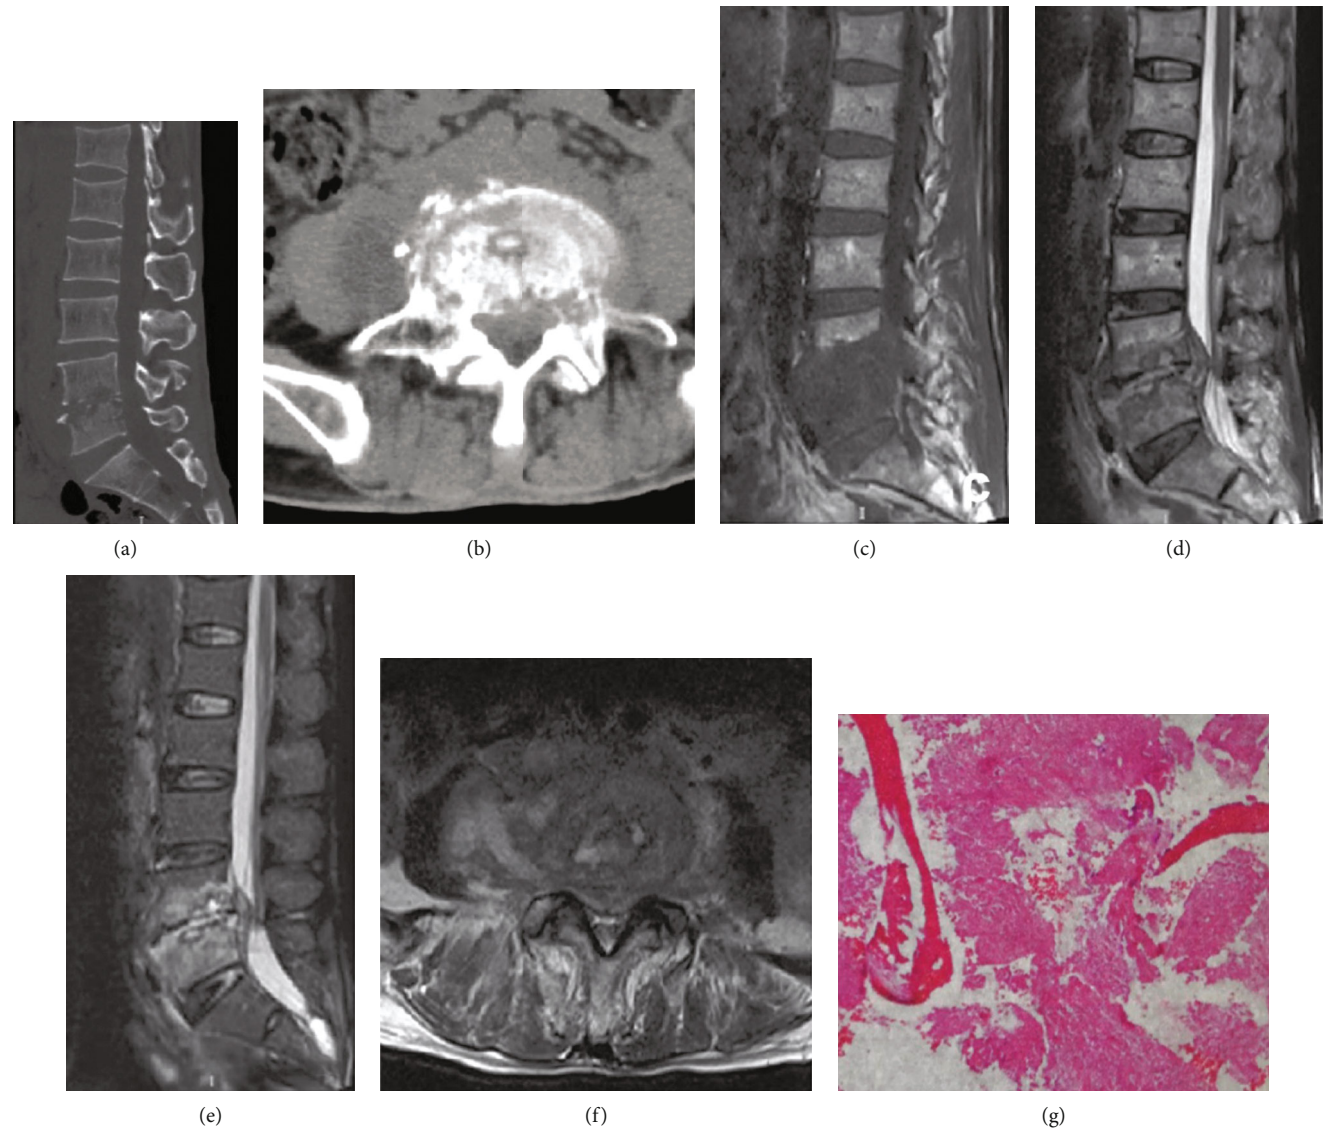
A 56-year-old male suffered from back pain for 4 months with no malignant tumor history. (a, b) lumbar CT showed L4 and L5 vertebral body bone destruction, narrow intervertebral disc, and sequestra formation. (c–f) Lumbar MRI indicated that L4 and L5 vertebral body destruction, subligamentous spread of abscess, and intervertebral disc were involved. (g) The score was 0 points and the preoperative diagnosis was spinal TB which was consistent with the postoperative pathological diagnosis (granulomatous inflammation).
